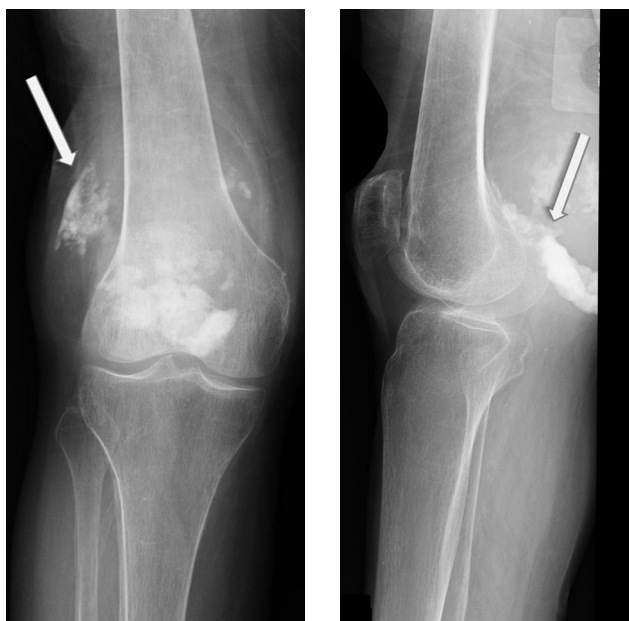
Anteroposterior (A) and lateral (B) radiographs of right knee show soft-tissue swelling and calcification (arrows).
